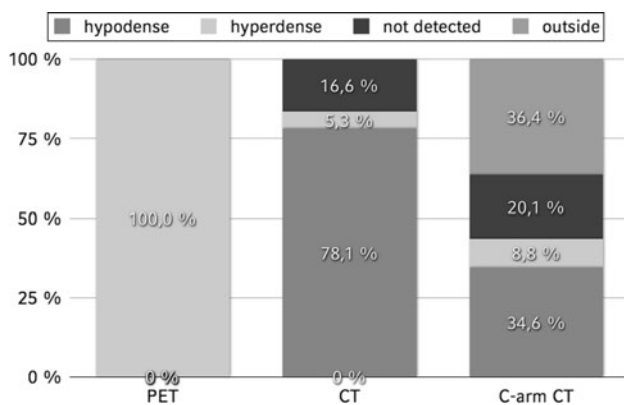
PET serves as the “gold standard” for the detection of liver lesions. Hypodense and hyperdense liver lesions, 71 and 5.3%, respectively, were detected by venous contrast-phase CT. Of all lesions, 8.8% were hyperdense in C-arm CT, and 34.6% were hypodense, showing a characteristic rim enhancement. Of the liver lesions, 16.6 and 20.1%, respectively, were detected neither by conventional CT nor by C-arm CT. Another 36.4% of all lesions were outside the field of view or the contrast-enhanced liver parenchyma in C-arm CT images
